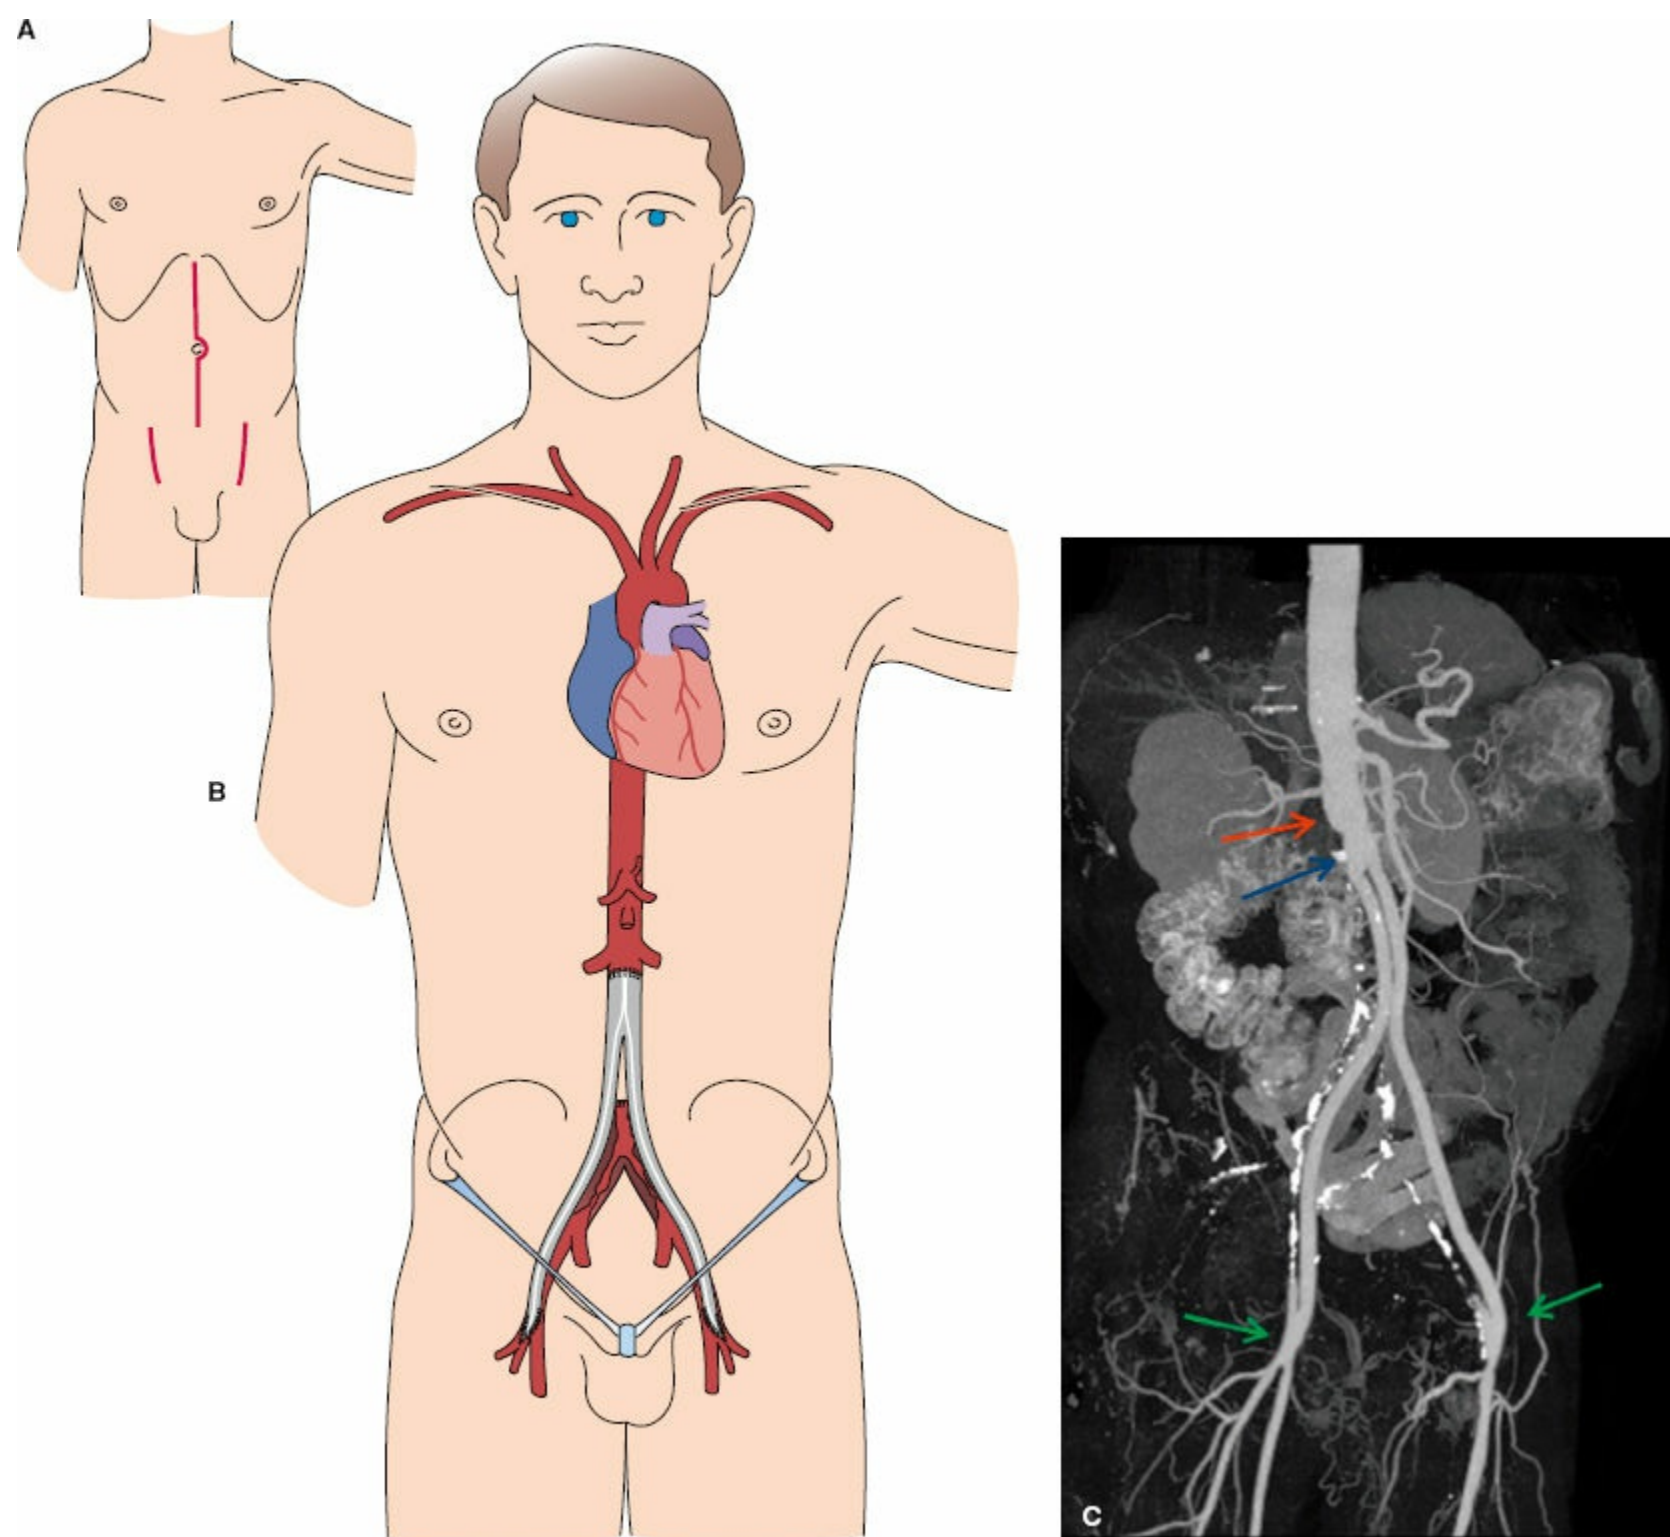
A: A midline abdominal incision and bilateral groin incisions overlying the common femoral arteries offer exposure for performance of aortobifemoral bypass. B: This image demonstrates an end-to-end proximal aortic to graft reconstruction with the respective graft limbs anastomosed end to side to the common femoral arteries. C: Computed tomographic angiographic postprocessed and reformatted image demonstrating open aortobifemoral arterial reconstruction of juxtarenal aortic occlusion (see Fig. 92-2, preoperative image) with prosthetic bifurcated graft. Note endarterectomy of aorta immediately distal to renal arteries (red arrow), followed by proximal end-to-end anastomosis between graft and aorta (blue arrow). Distal anastomosis to femoral arteries is performed in end to side fashion (green arrows).
